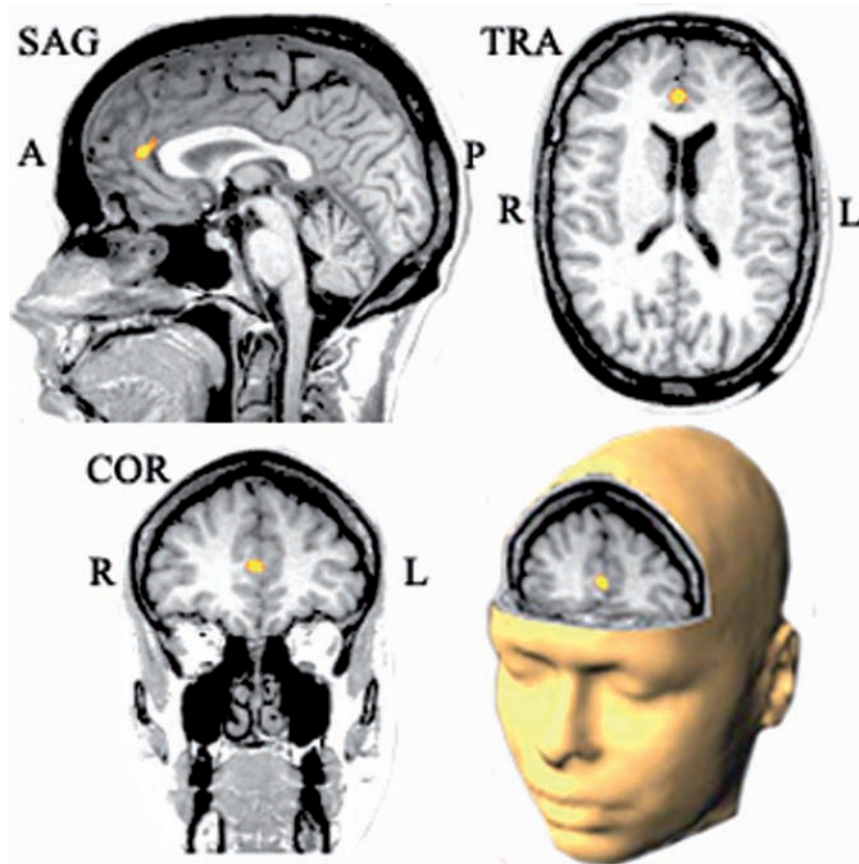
Subtraction ictal single-photon emission computed tomography co-registered to MR (SISCOM) shows significant bilateral hyperperfusion of the pACC (Schindler *et al.*, 2001).
